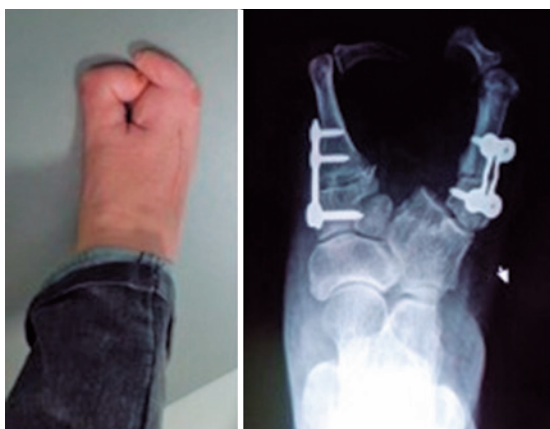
Photo and X-ray of patient's right foot at 6 postoperative months.
